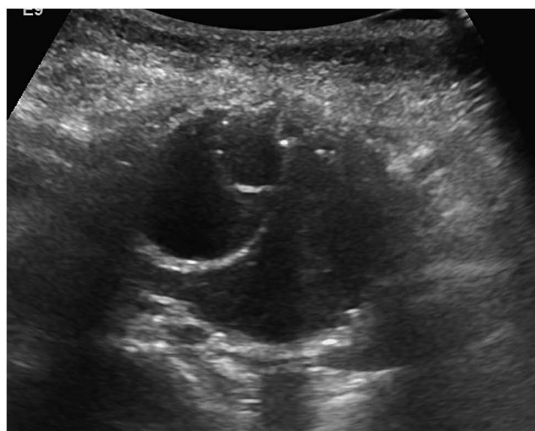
Ultrasound image (B mode) of the slow endoleak case. This image demonstrates a large abdominal aortic aneurysm and stent graft.
